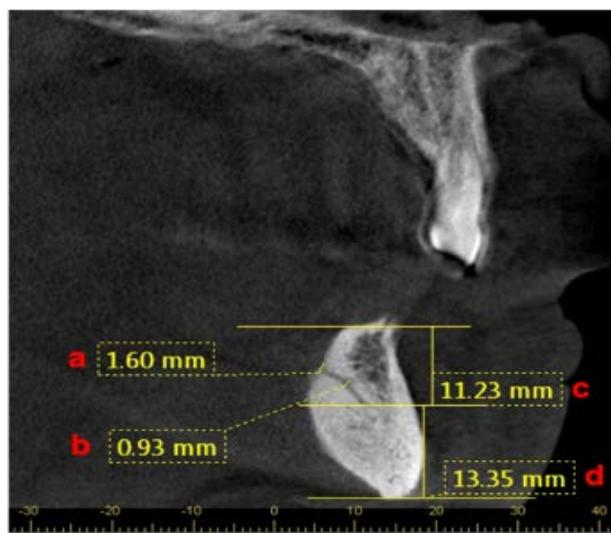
Linear measurements on axial mandibular CBCT sections. (a) diameter of the LF (b) maximum diameter of the artery (c) the distance between the LF and the AR (d) the distance between the LF and the MB
